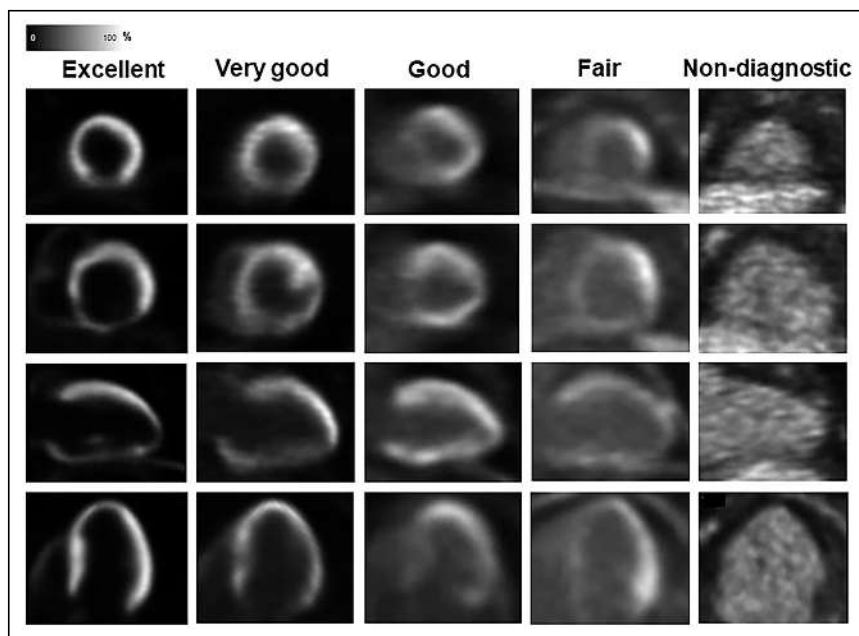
Myocardial  $^{18}\text{F}$ -FDG image quality was evaluated according to 5-point score system.
